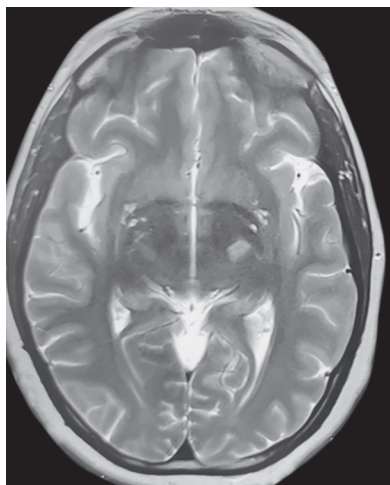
Magnetic resonance imaging brain T2 image showing hyperintense lesion in left thalamus
